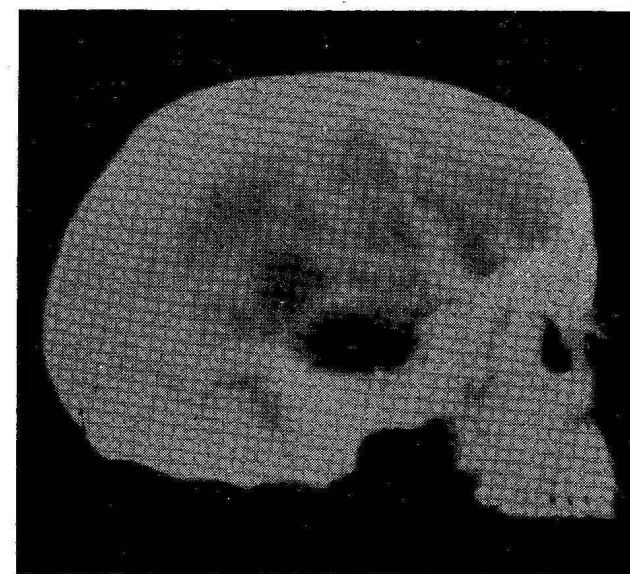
Lateral X-ray graph of the skull of the young adult man TD9 showing changes in the volume and profile of the sella turcica.*
